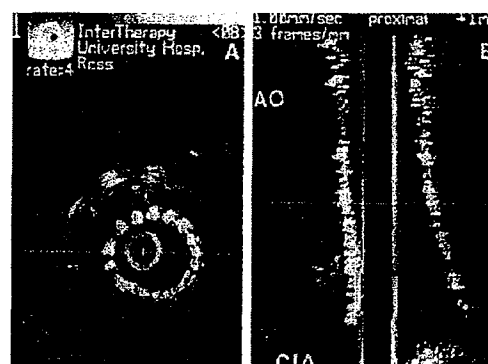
Stent (PET) dislocation demonstrated by intravascular ultrasound. A A cross-section at the level of the aortic bifurcation shows the deployed stent floating in the aorta (arrowheads). B Sagittal section at the level of the aortic bifurcation. The distal part of the stent is still attached at the ostium (arrowhead) of the common iliac artery (CIA) and the proximal part is floating in the aorta (AO).
